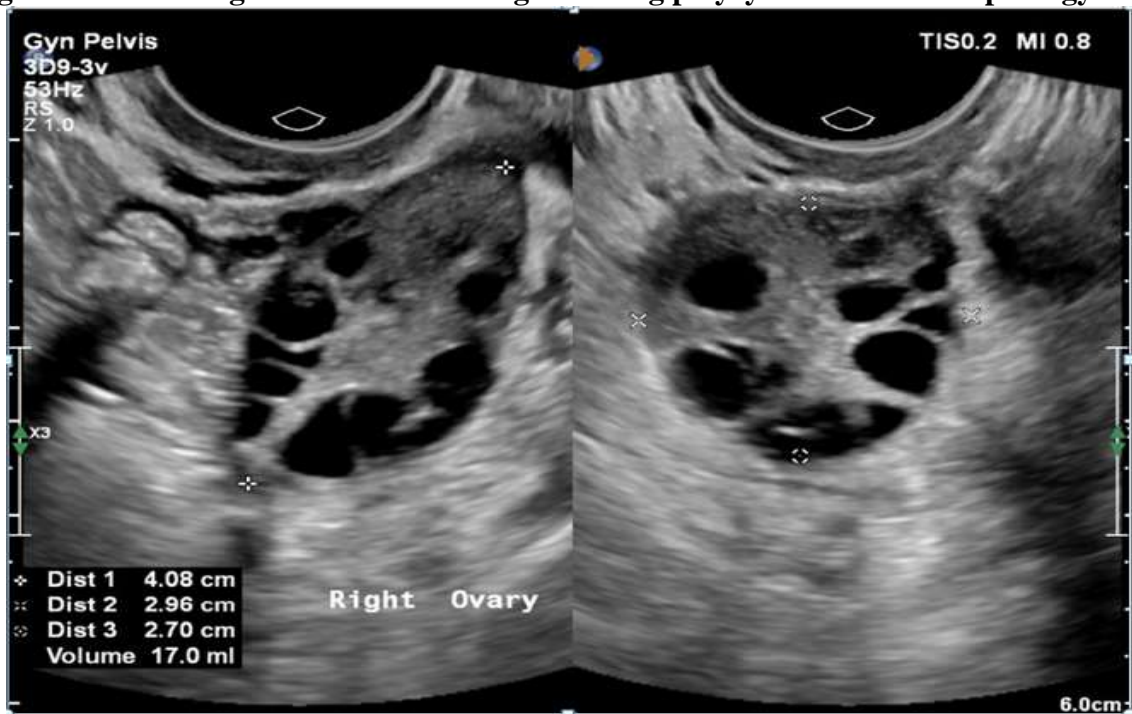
Transvaginal ultrasound image showing polycystic ovary
